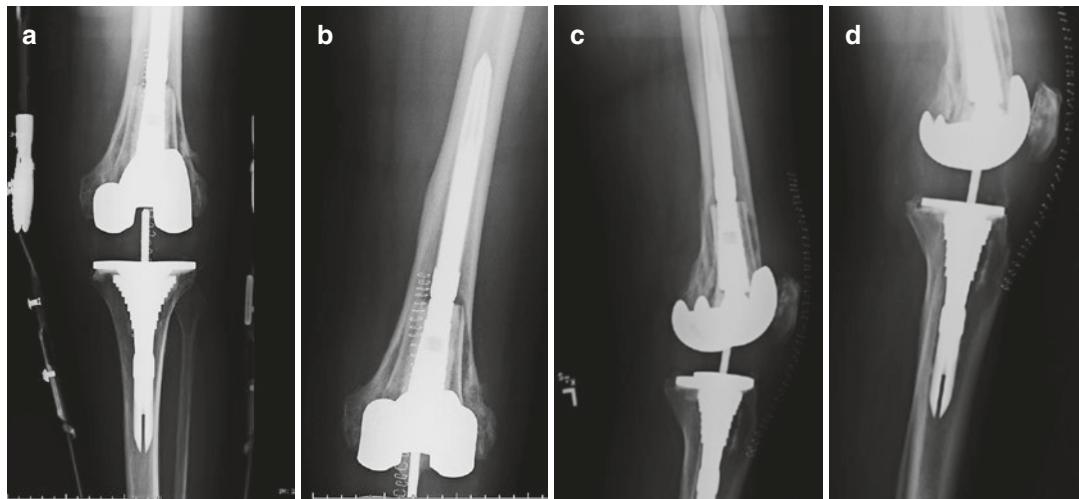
Immediate postoperative radiographs (a–d) after revision total knee arthroplasty utilizing a distal femoral allograft implanted via an intussusception technique
